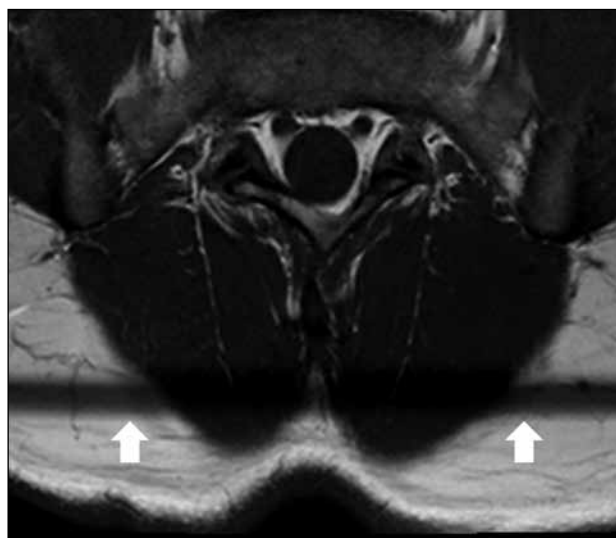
Axial T1-weighted image of the lumbar spine with multi-angle acquisition. Hypointense signal band (white arrows) is observed due to cross-excitation with saturation effect.
